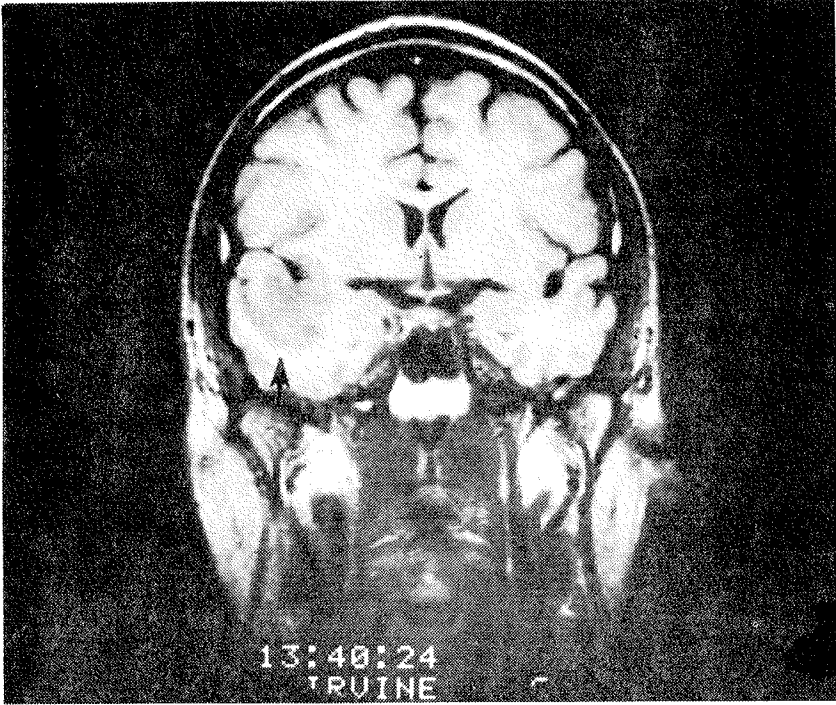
Temporal Lobe Glioma. Coronal MR image shows low intensity area (grey) in superior aspect of temporal lobe (arrow). The temporal lobe is expanded.
